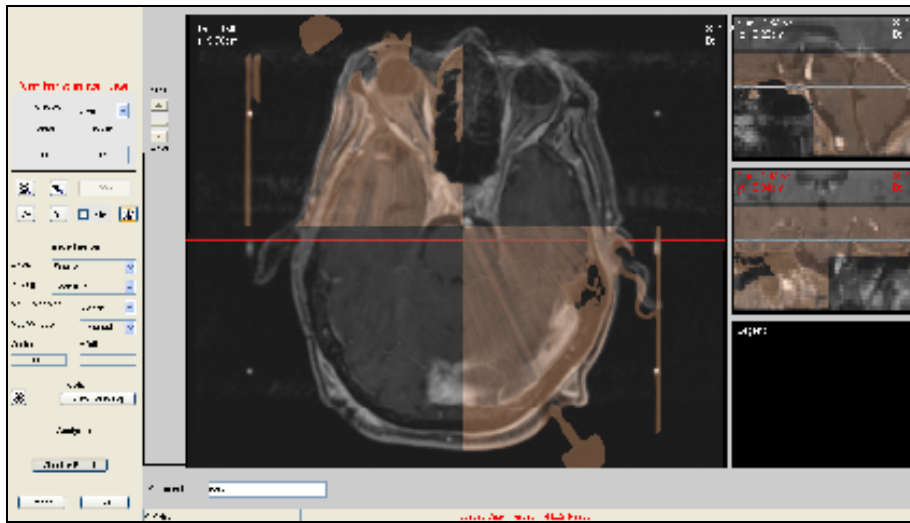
CERR- based image registration of the GammaPlan image set (CT) with that (MR) used for Eclipse/Helios planning at time of recurrent tumor re-treatment.
